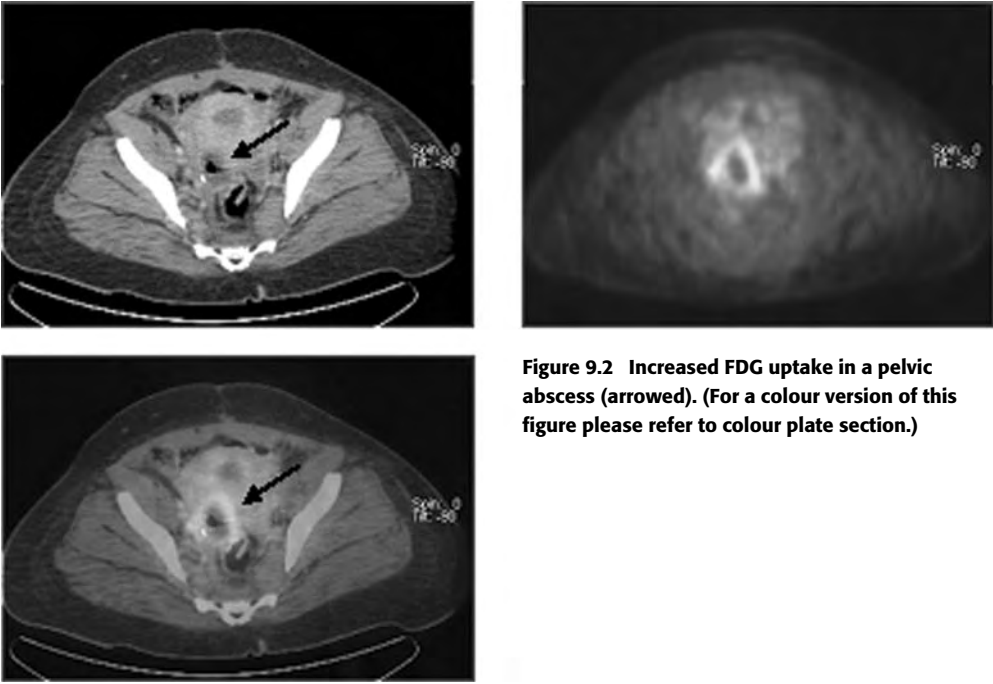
Increased FDG uptake in a pelvic abscess (arrowed). (For a colour version of this figure please refer to colour plate section.)
